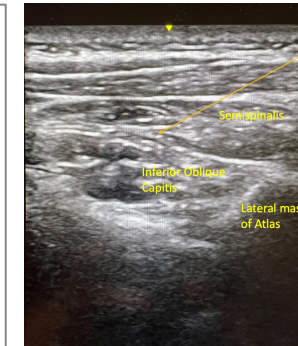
Ultrasound image of injection target and anatomical landmarks used in the case
